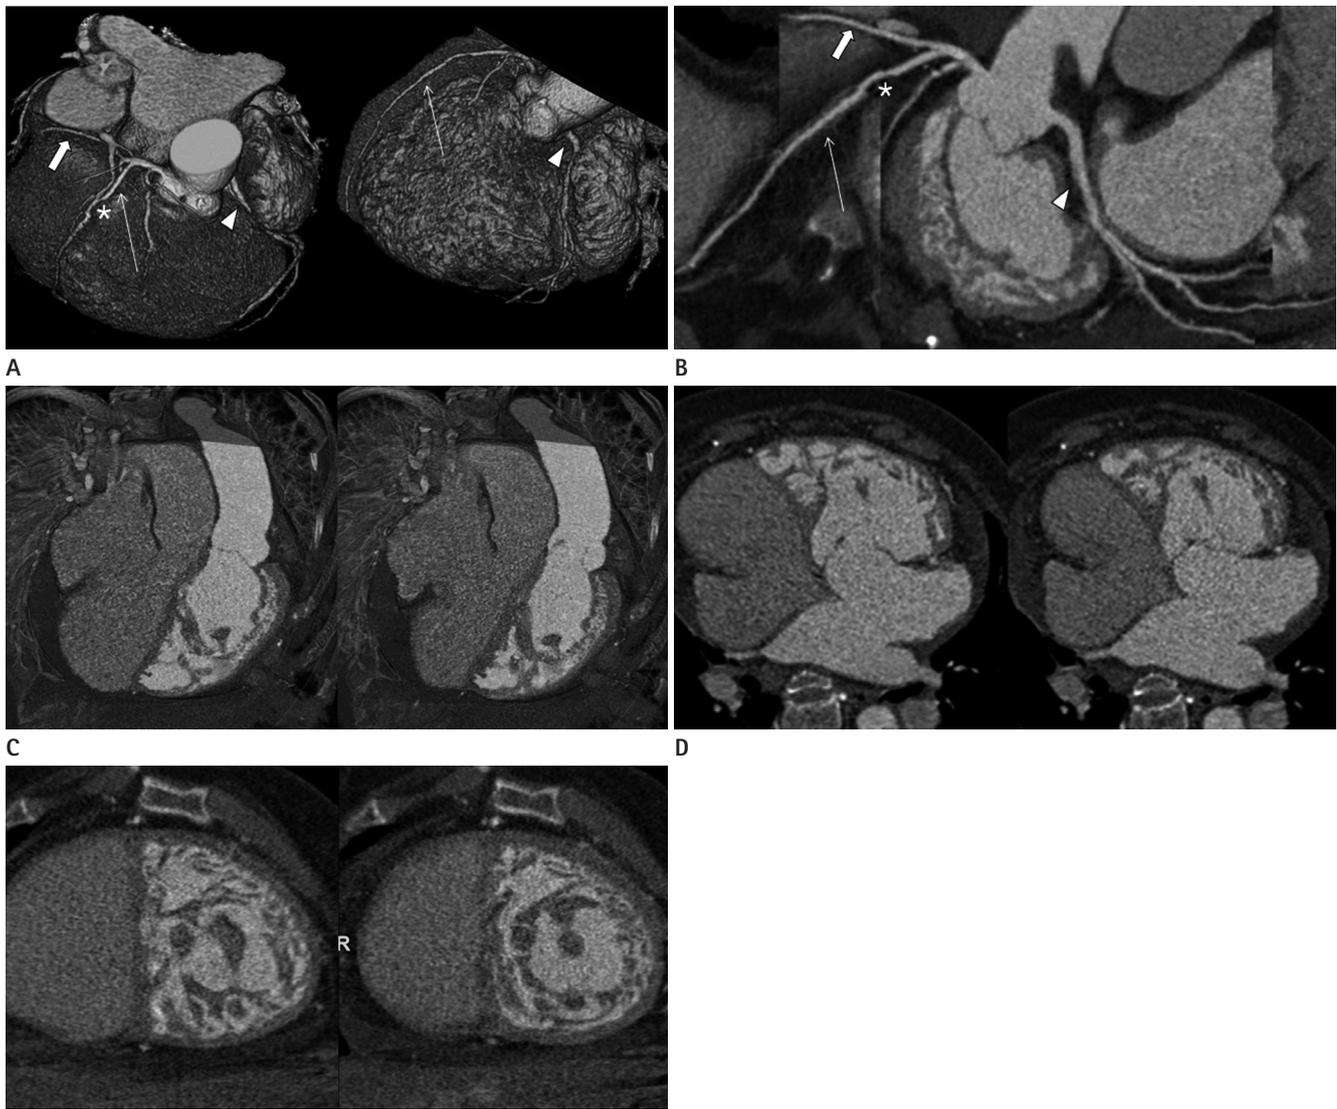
Cardiac CT performed on 69-year-old female.
